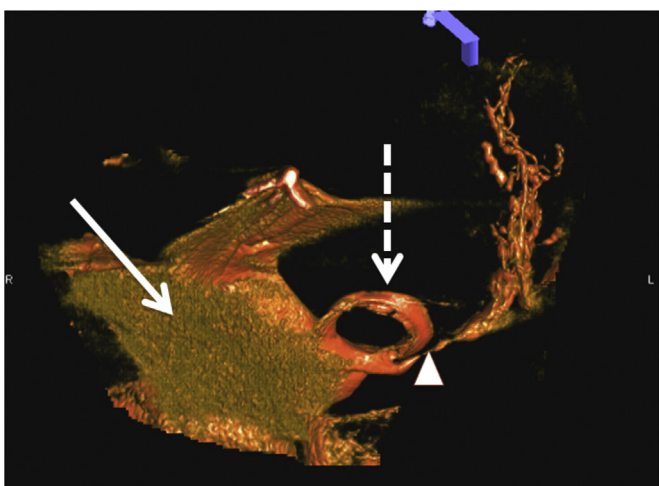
Three dimensional reconstruction of a Cone beam CT of the pelvis after injection of contrast through the pigtail drainage catheter (dashed arrow) demonstrating a large collection (arrow) and a left iliac lymphatic leak (arrowhead).
